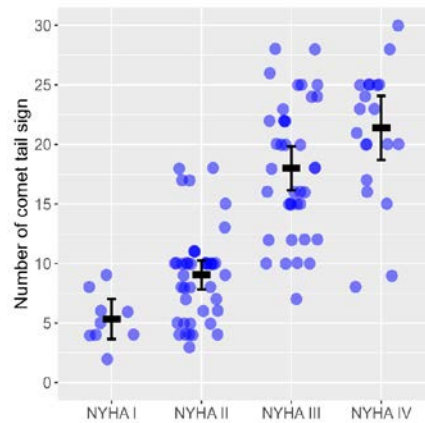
Number of ultrasound lung “comets” in patients from different classes of the New York Heart Association (NYHA) classification system.
